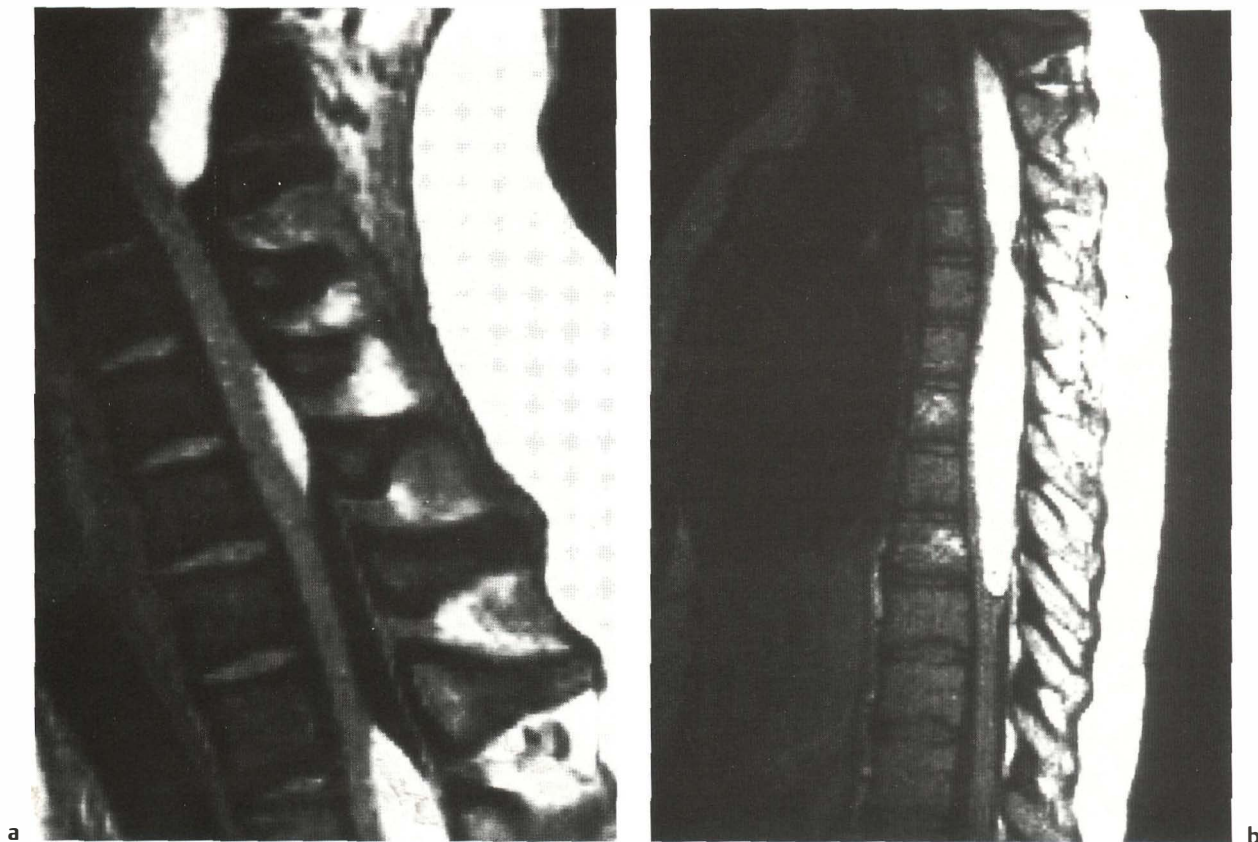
Intramedullary spinal cord lipomas (case 148). a–c Multiple lipomas located posteriorly within the spinal cord, which are well-delineated and strongly hyperintense compared to the spinal cord in these T1-weighted images. d The post-myelogram CT scan shows that the masses are hypodense. These findings on both MRI and CT are pathognomonic
